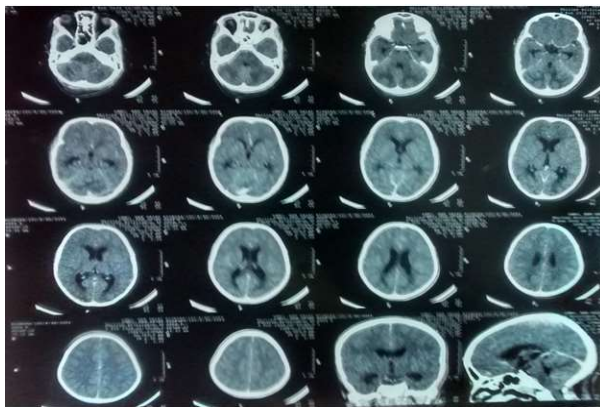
CT Head showing cerebellar edema and dilatation of ventricles
